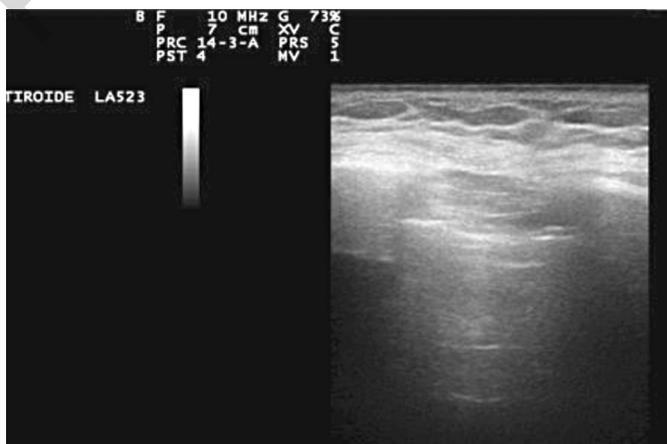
CUS examination showing absence of lung sliding, absence of B-lines and absence of lung pulse, diagnostic for PTX. CUS: chest ultrasound; PTX; pneumothorax.
